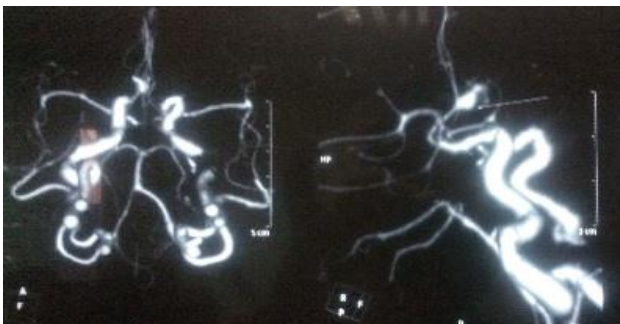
CTA brain showing Acom aneurysm.
